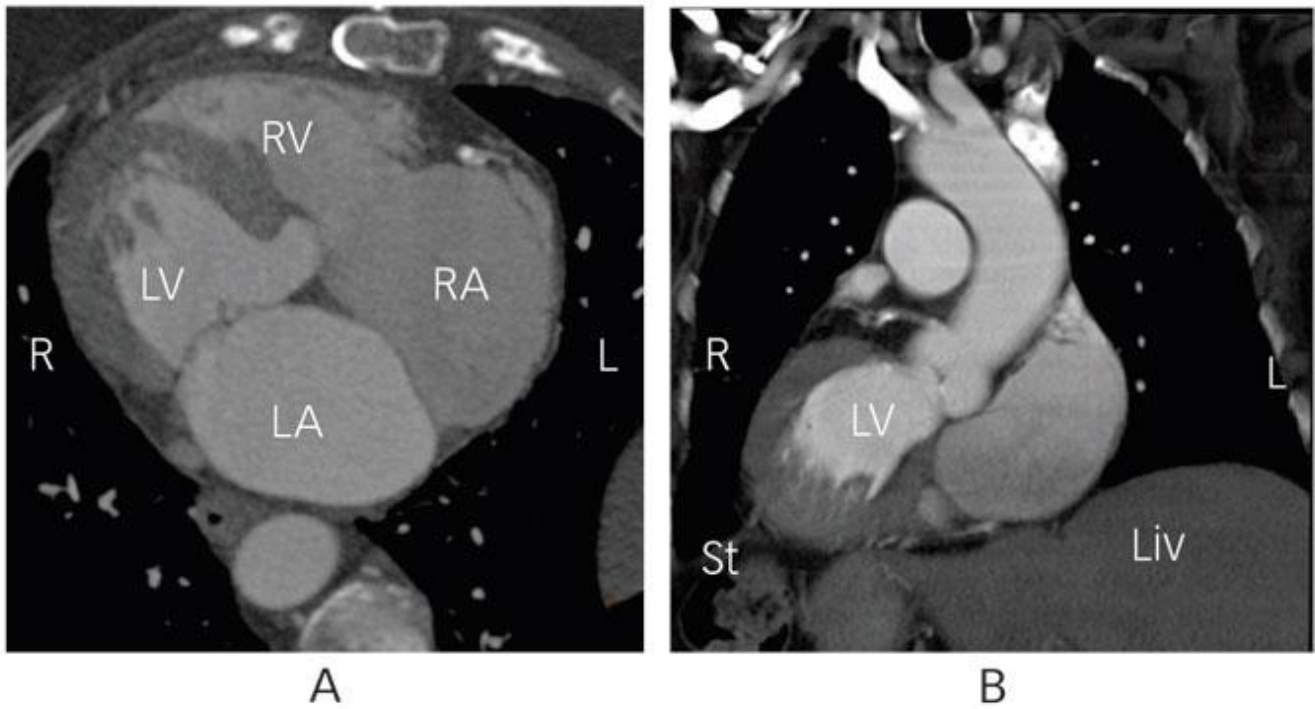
64-Slice CT angiograms showing situs inversus totalis with dextrocardia (A, coronal view; B, axial view).
